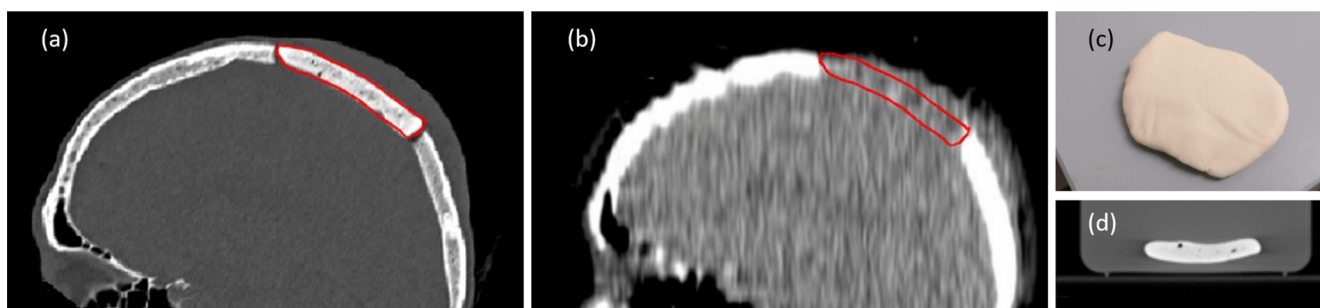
One patient's barium-contrasted plastic-based cement implant (contoured in red), imaged with (a) nominal 100 kVp CT and (b) nominal 3.5 MV CT, alongside (c) a photograph and (d) a nominal 120 kVp CT of the bone cement sample used in this work.
